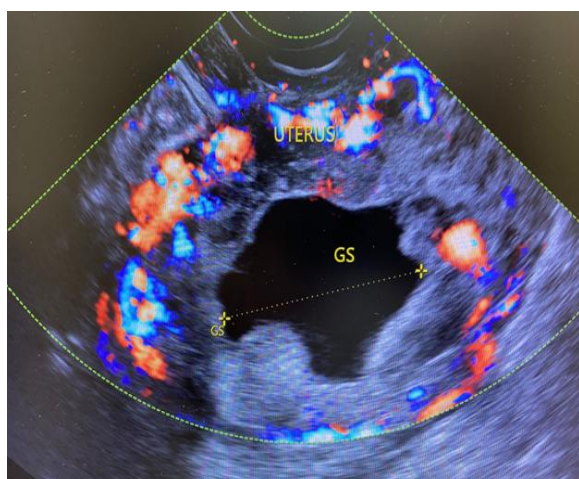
A transvaginal ultrasound showing the empty gestational sac with abnormal active vessel flow in the myometrium
